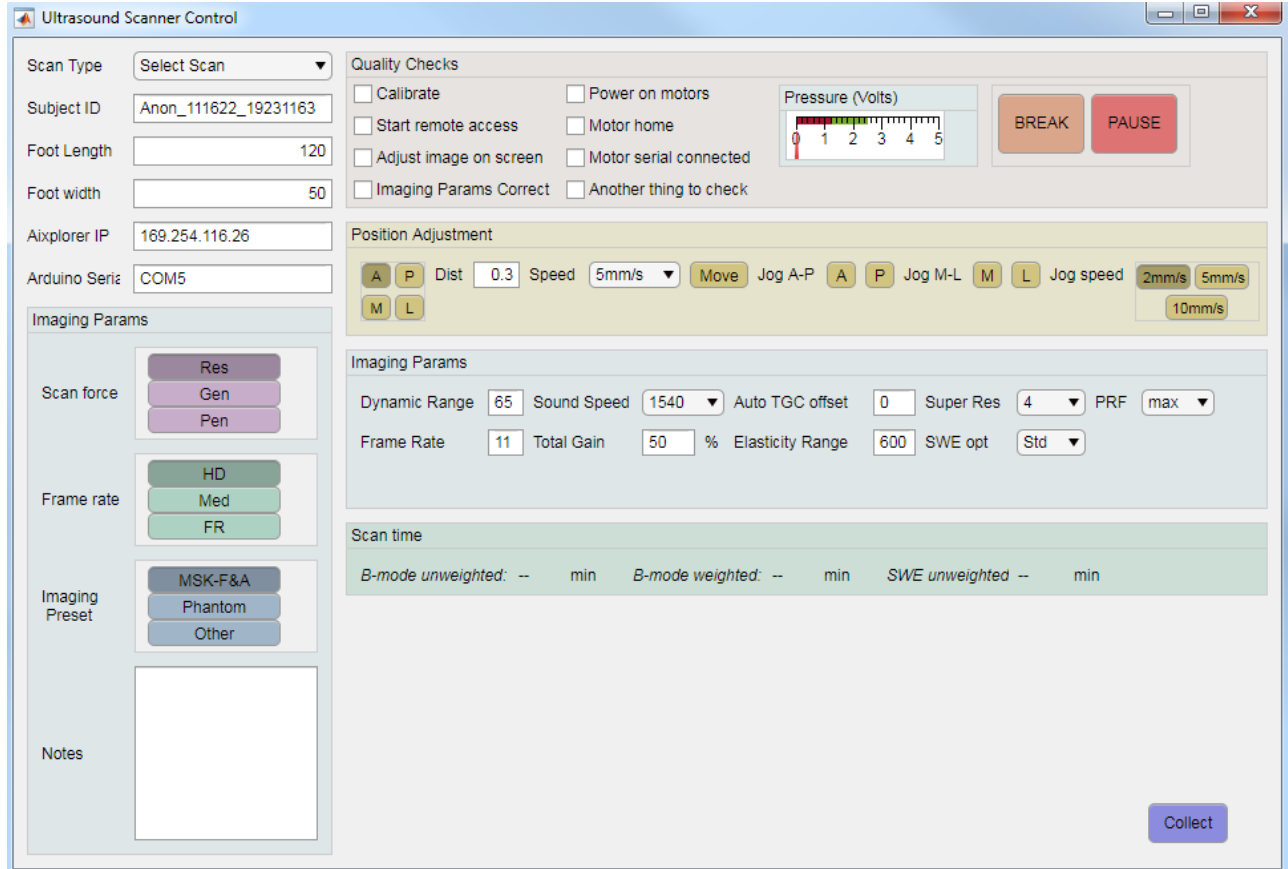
The Graphical User Interface through which the operator interacts with the scanning software during collection of a volumetric ultrasound scan.
